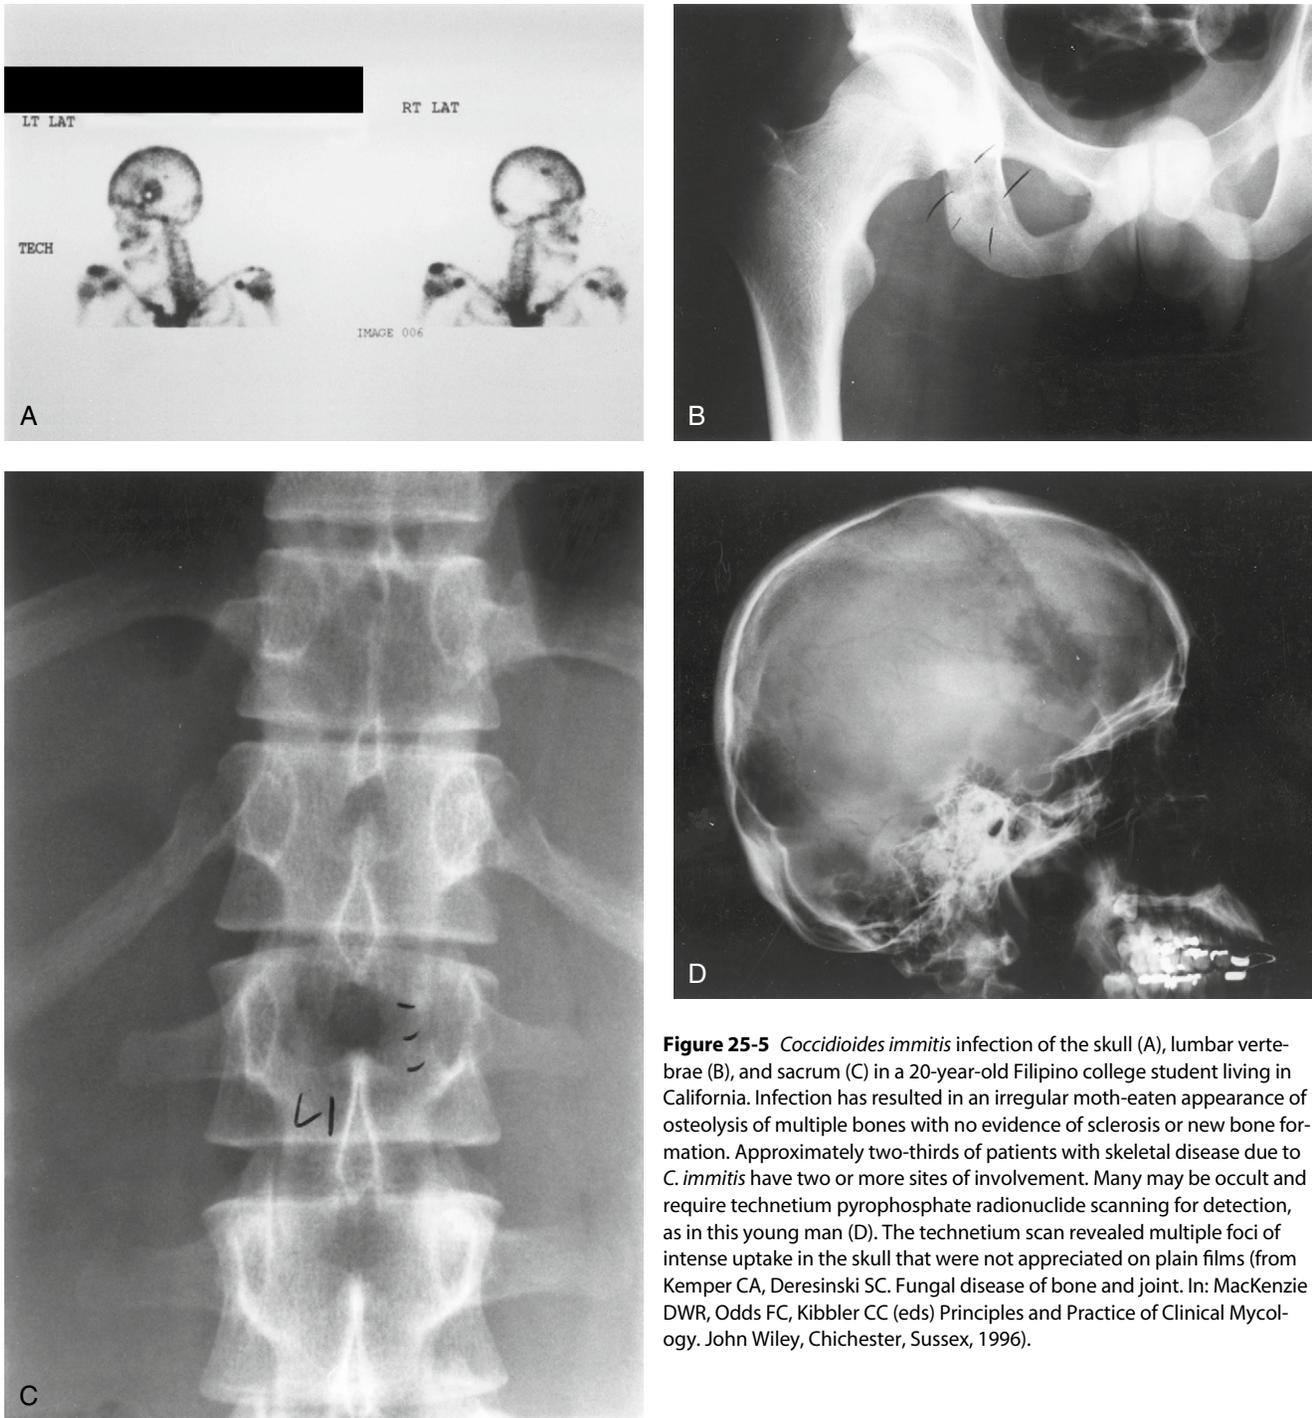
Coccidioides immitis* infection of the skull (A), lumbar vertebrae (B), and sacrum (C) in a 20-year-old Filipino college student living in California. Infection has resulted in an irregular moth-eaten appearance of osteolysis of multiple bones with no evidence of sclerosis or new bone formation. Approximately two-thirds of patients with skeletal disease due to *C. immitis* have two or more sites of involvement. Many may be occult and require technetium pyrophosphate radionuclide scanning for detection, as in this young man (D). The technetium scan revealed multiple foci of intense uptake in the skull that were not appreciated on plain films (from Kemper CA, Deresinski SC. Fungal disease of bone and joint. In: MacKenzie DWR, Odds FC, Kibbler CC (eds) Principles and Practice of Clinical Mycology. John Wiley, Chichester, Sussex, 1996).
